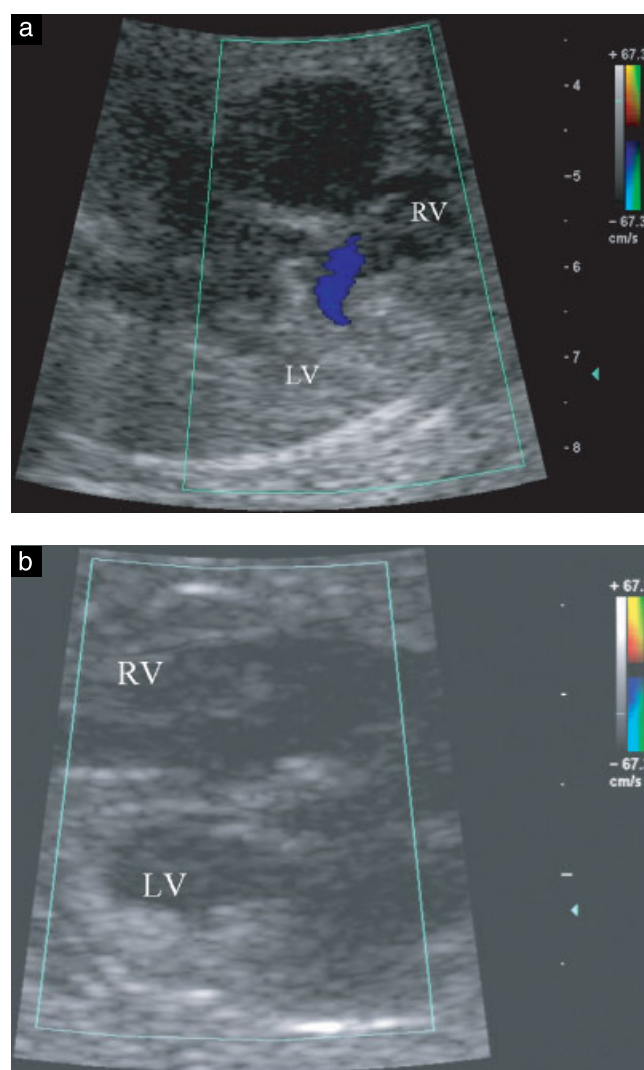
(a) Color Doppler ultrasound image showing small subaortic outlet defect, which did not close spontaneously. (b) Gray-scale four-chamber view of the same fetus. The subaortic ventricular septal defect is not visible in this mode. LV, left ventricle; RV, right ventricle.
